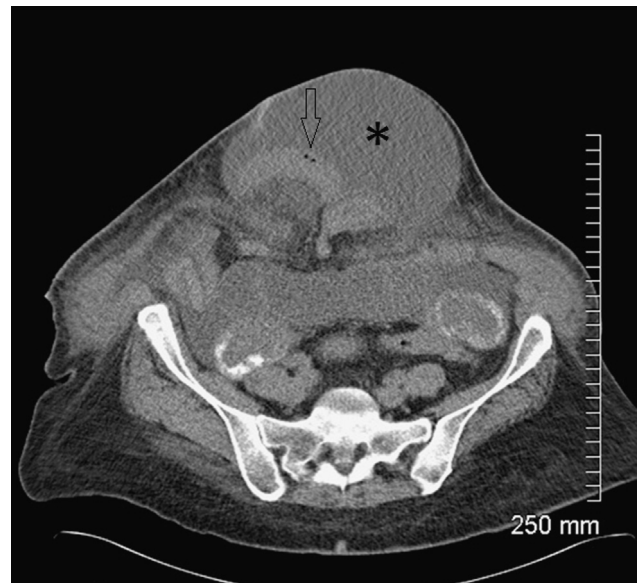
Axial CT scan demonstrates an umbilical hernia with loops of small bowel (arrow) and ascites (asterisk) in the hernia sac.
